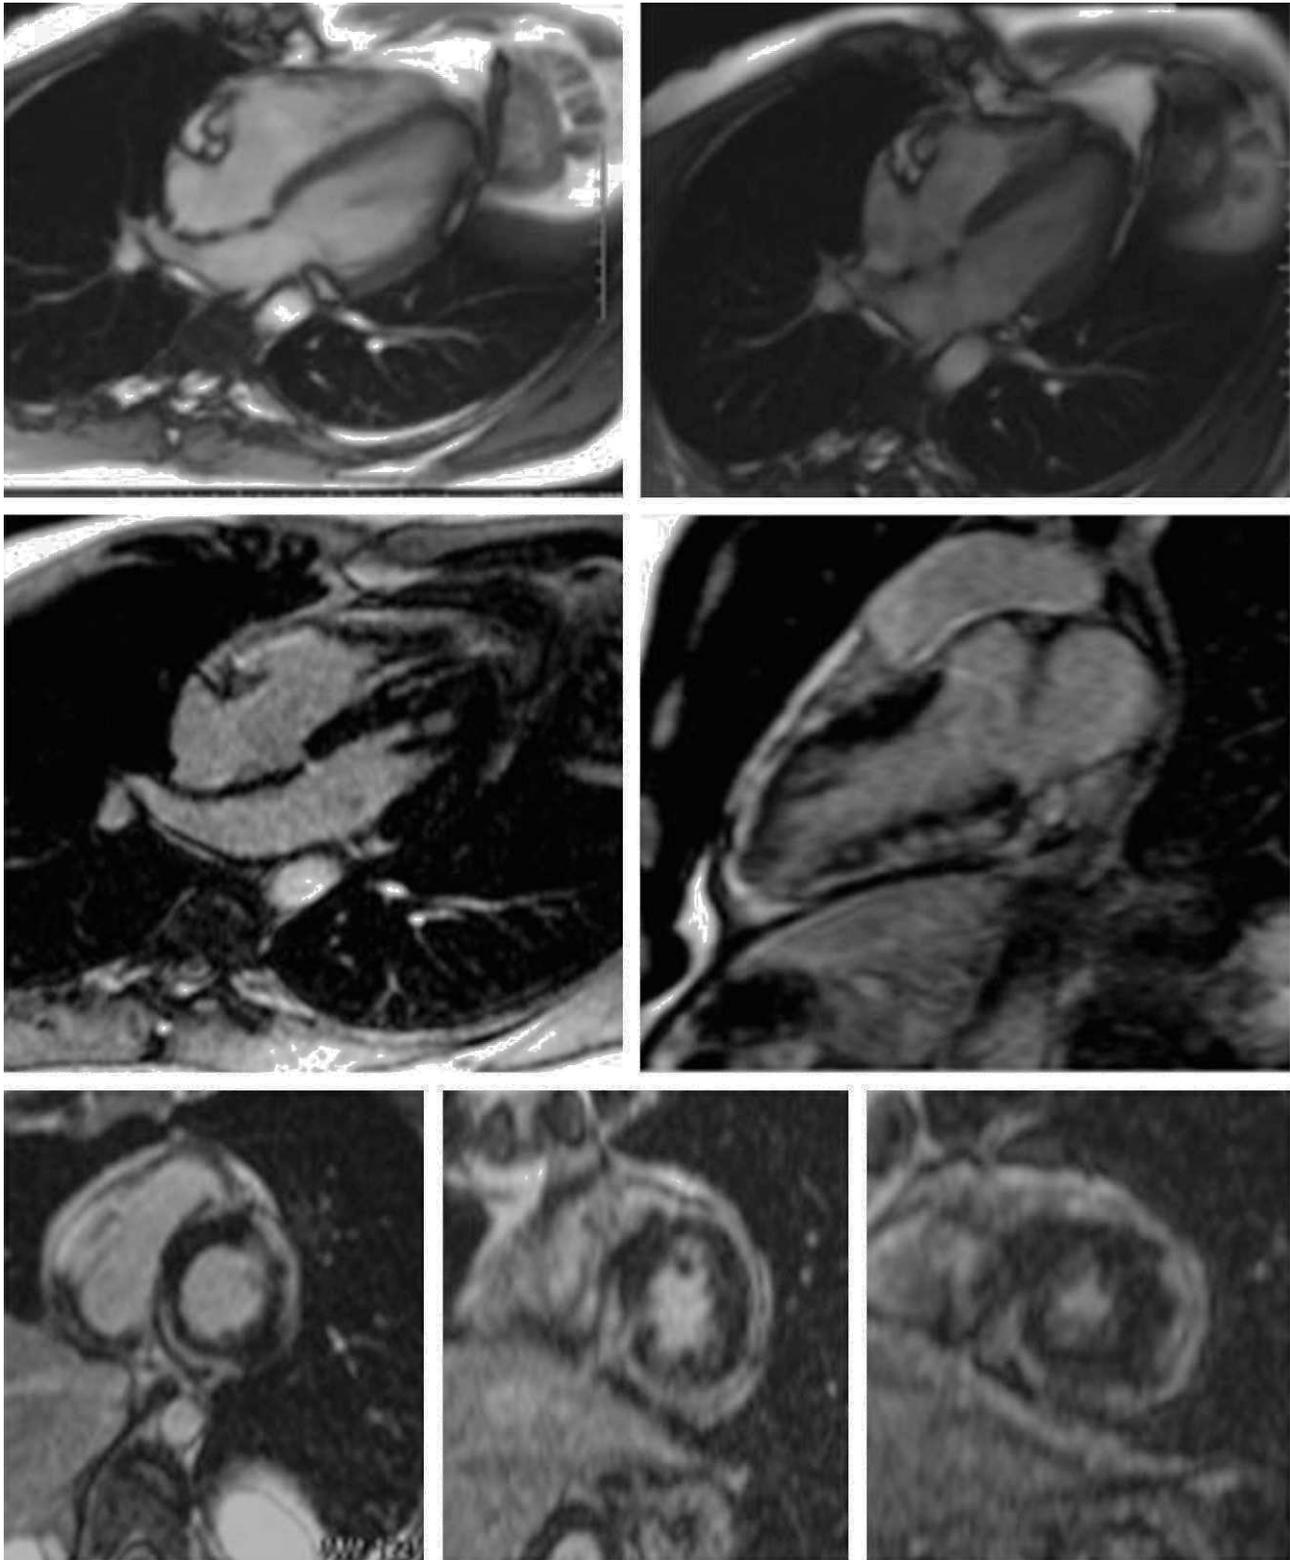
Left ventricular arrhythmogenic cardiomyopathy. Turbo FLASH viability images obtained in cuts along the short axis at the basal level with fatty saturation (central image) and without fatty saturation (left image) and multiplanar reconstruction of multislice computed tomography images to obtain a slice of the basal short axis, in which an undulating epicardial border is observed indicative of fibroadipose epicardial infiltration.
